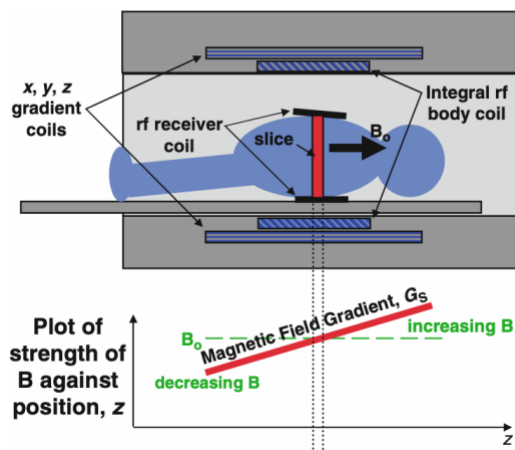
Magnetic field gradients within a MRI scanner.
